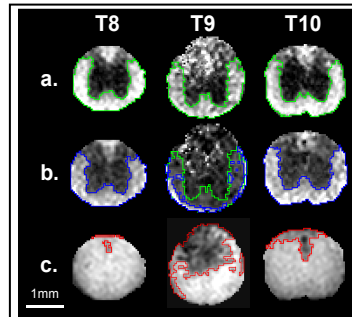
The injury patterns in the hyper-acute T2W/DWI maps in the epicenter (T9) and remote sites (T8 and T10): (a) AI maps provide contrast between GM and WM allowing total VWM (green) estimation, even in the injured cords. (b) D_{\parallel} maps show the axonal injury pattern as the decreased D_{\parallel} (the blue ROI denotes spared WM; the green ROI indicates total WM). (c) T2W images show the regions of GM and dorsal WM hematomas.
